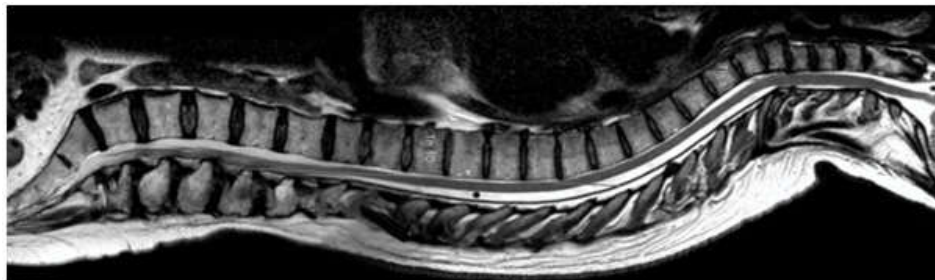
Mid-line MRI of the spinal column. The cervical enlargement fills almost the entire spinal canal at the level. In the thoracic segments, the spinal cord is positioned anteriorly leaving a significant space between the posterior dura and the spinal cord. At the lumbar level the latter space disappears almost completely.
